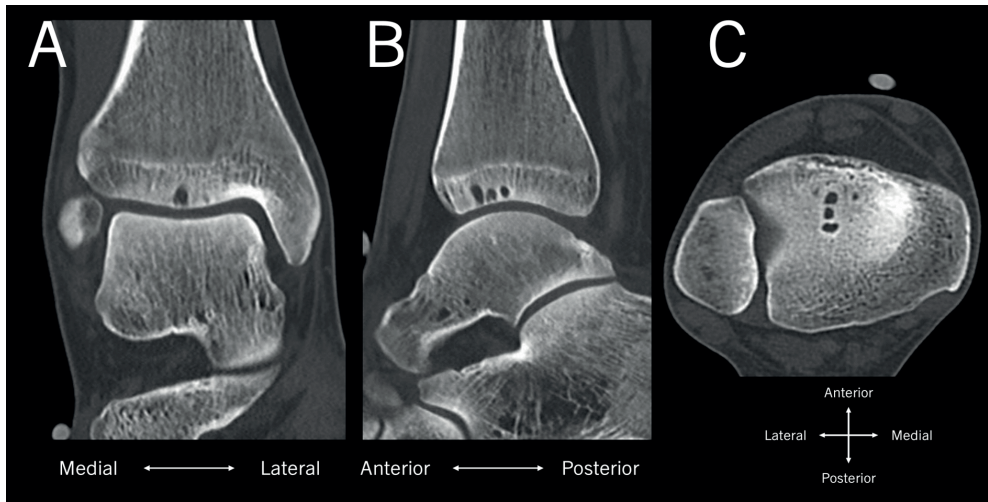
CT-scan of the ankle joint showing an OLTP on the antero-central tibial plafond, as depicted from the coronal view (A), sagittal view (B), and axial view (C).
